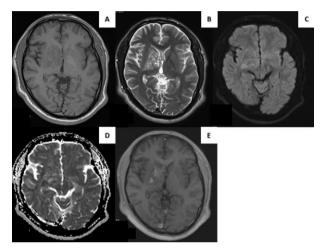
Preoperative cranial MRI demonstrates a right basal ganglia lesion with mild hypointensity on the T1-weighted sequence (A) and heterogeneous hyperintensity with microcystic nodules on the T2-weighted sequence (B). The lesion shows patchy restricted diffusion in the form of a patchy high signal with a high B value of DWI (C) and a low signal apparent diffusion coefficient (D). The lesion shows patchy enhancement in the postcontrast T1-weighted sequence (E).
